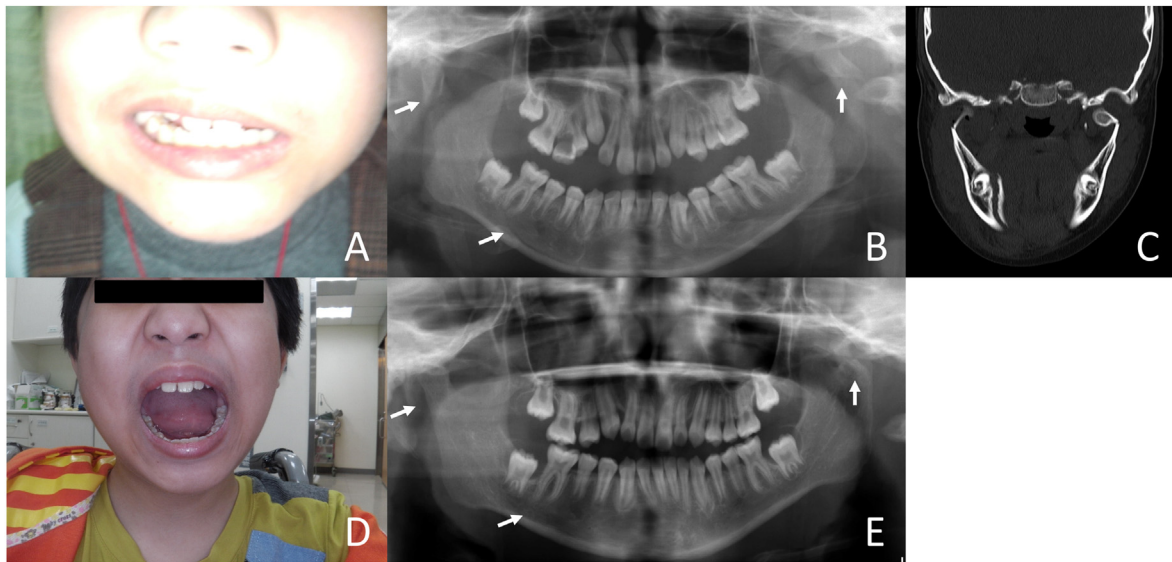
Pre- and post-treatment photographs and radiographs of our patient. (A) Pre-operation, limited mouth opening and malocclusion was noted. (B and C) Radiographs showed fracture of right mandibular body and bilateral condyles. (D) 2 months post-operation, the mouth opening was wide and oral function was regained. (E) 9 months post-operation, radiograph showed good healing of mandible.
